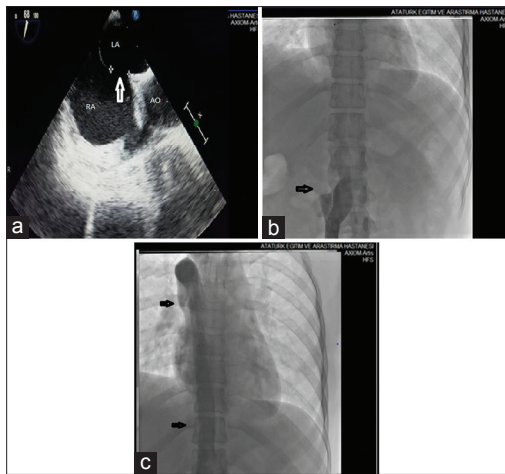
(a) Transesophageal appearance of the secundum atrial septal occluder before closure (white arrow), (b) Interrupted section of inferior vena cava, (c) The azygos continuation of interrupted inferior vena cava
